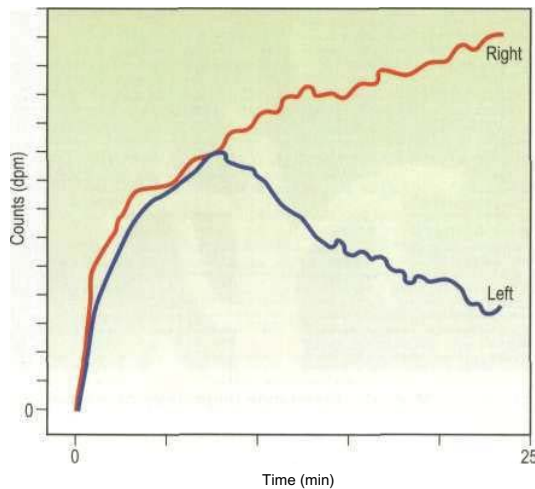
Dynamic scintigram. Note the progressive rise of the right kidney curve to a plateau (in contrast to the normal left kidney curve) owing to urinary tract obstruction on the right side.
